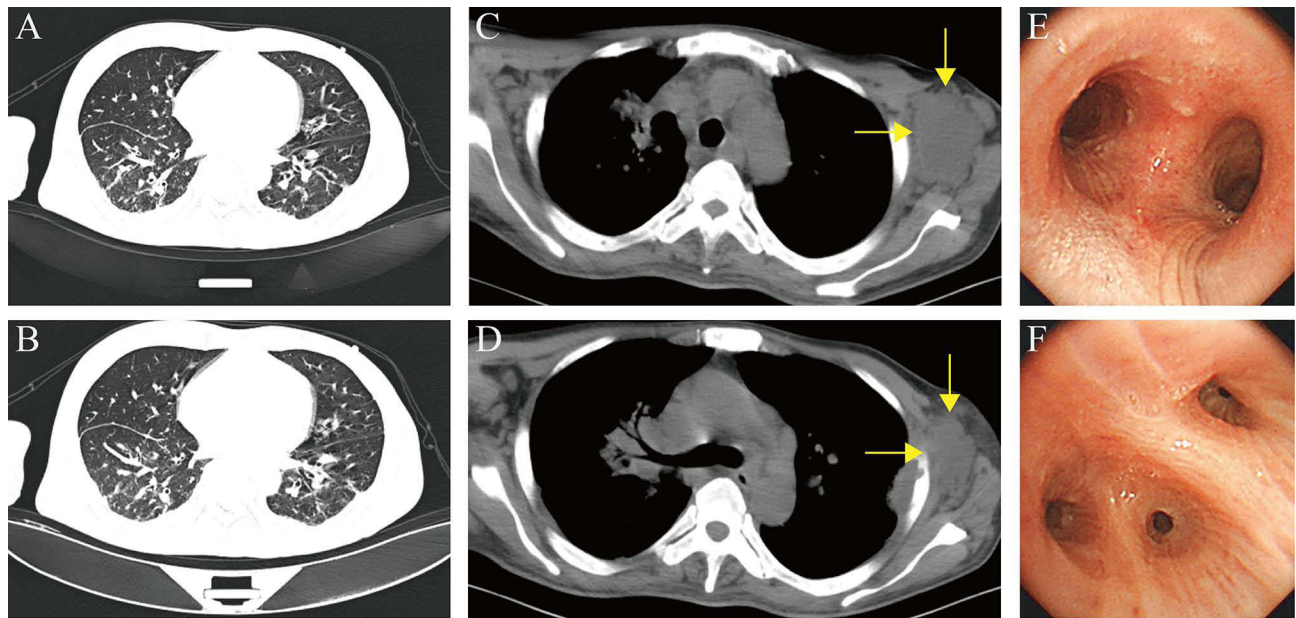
(A–F) Chest CT and bronchoscope. A and B indicate infectious lesions in both lungs. (C and D) yellow arrows show local bone destruction in the left 4th rib and flaky axillary low-density shadows. (E and F) show chronic inflammatory changes in the bilateral bronchus with mild stenosis of some lumens, tubercles, and right middle lobe mucous tubercles.
